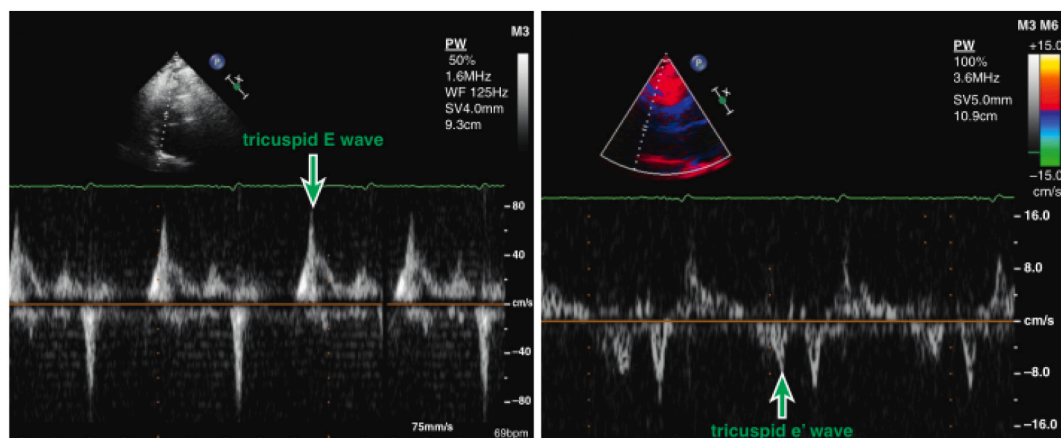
In patients in sinus rhythm, RAP was estimated by using the ratio of early tricuspid inflow and early diastolic tissue Doppler tricuspid annular velocities (E/e') [37].
